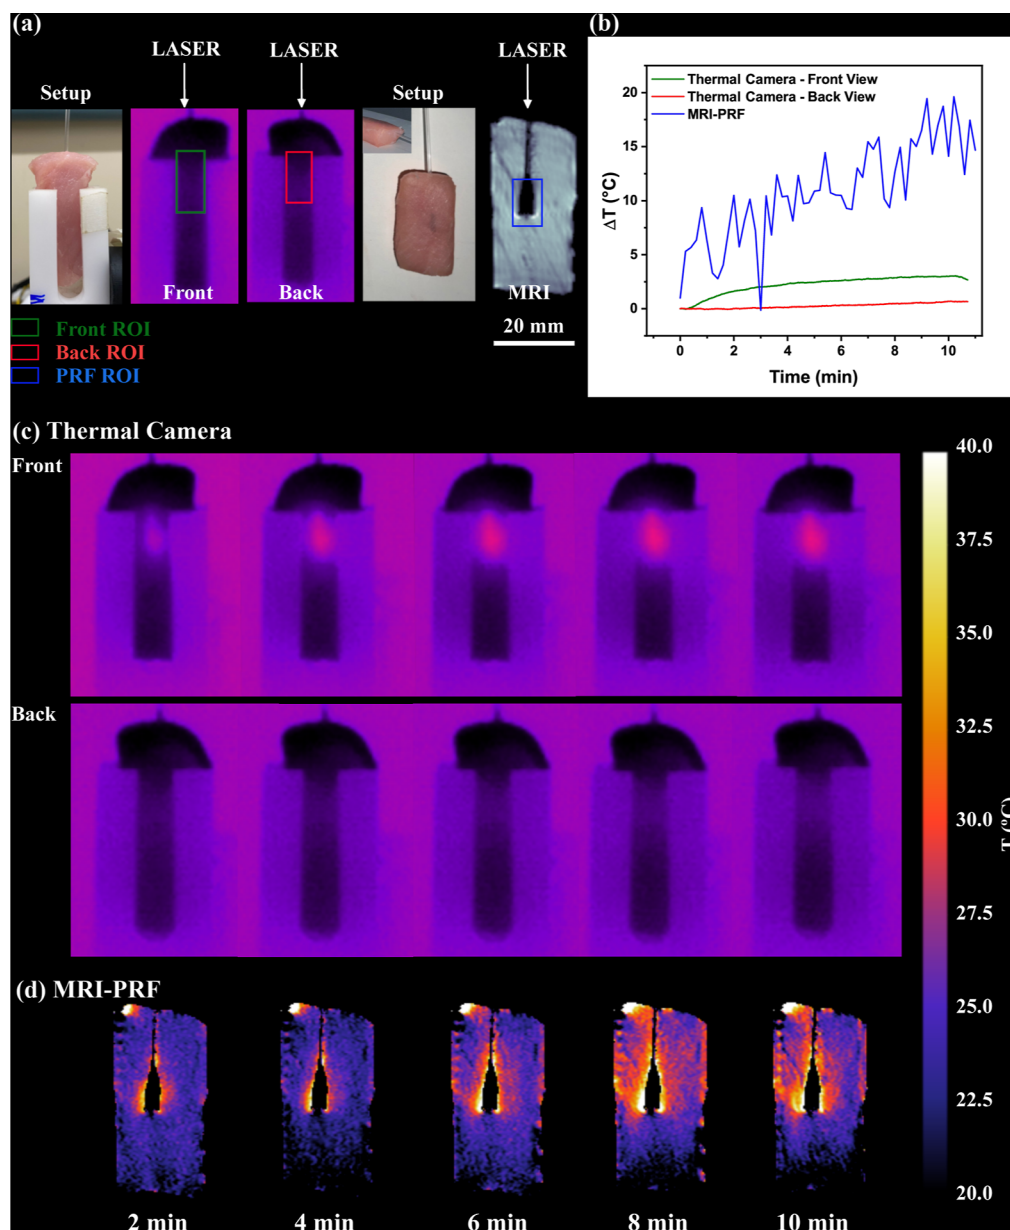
(a) From left to right: setup for the thermal camera study containing a pork loin and sample holder; thermal camera images of the front and back of the setup; setup for the MRI-PRF study with an inset showing the placement of the capillary tube; and reconstructed GRE MRI image of the pork loin with the inserted capillary filled with $10\ \mu\text{L}$ of MnFe_2O_4 NPs at $10\ \text{mg}\cdot\text{mL}^{-1}$. ROIs and fiber optic laser positions are highlighted. (b) Temperature variation during the studies for a laser fluence of $1.25\ \text{W}\cdot\text{cm}^{-2}$. (c) 2D images obtained from the thermal camera study at different times during NP-mediated PTT. (d) 2D temperature variation maps obtained from MRI-PRF thermometry at different times during NP-mediated PTT.
